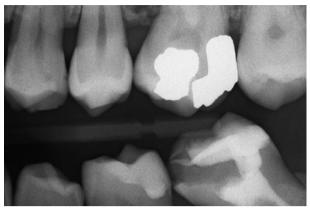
Bitewing radiograph shows the presence of a lesion near the pulp which deeply involves the distal cervical step.
